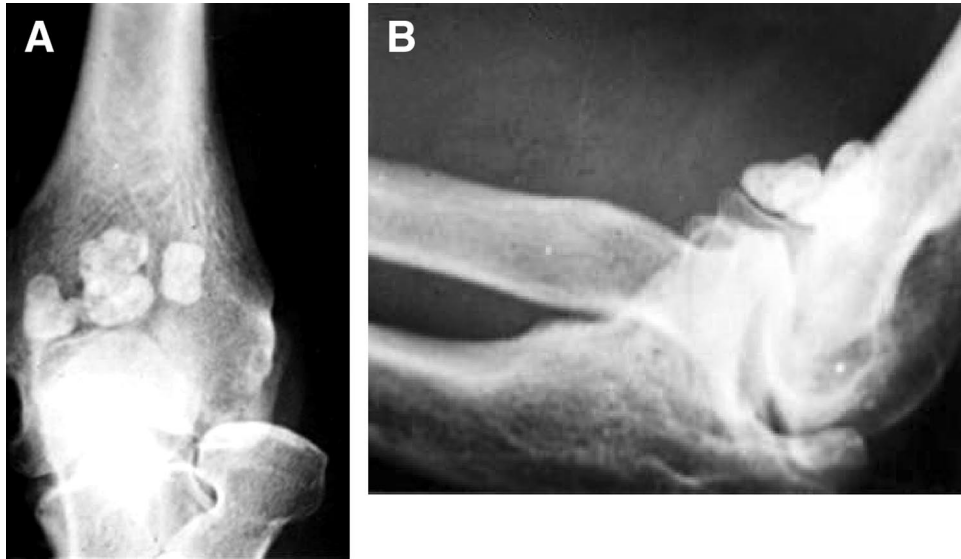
(A) AP and (B) Lateral radiographs of an elbow with arthritis and many loose bodies (Copyright Kevin D. Plancher, M.D.).
